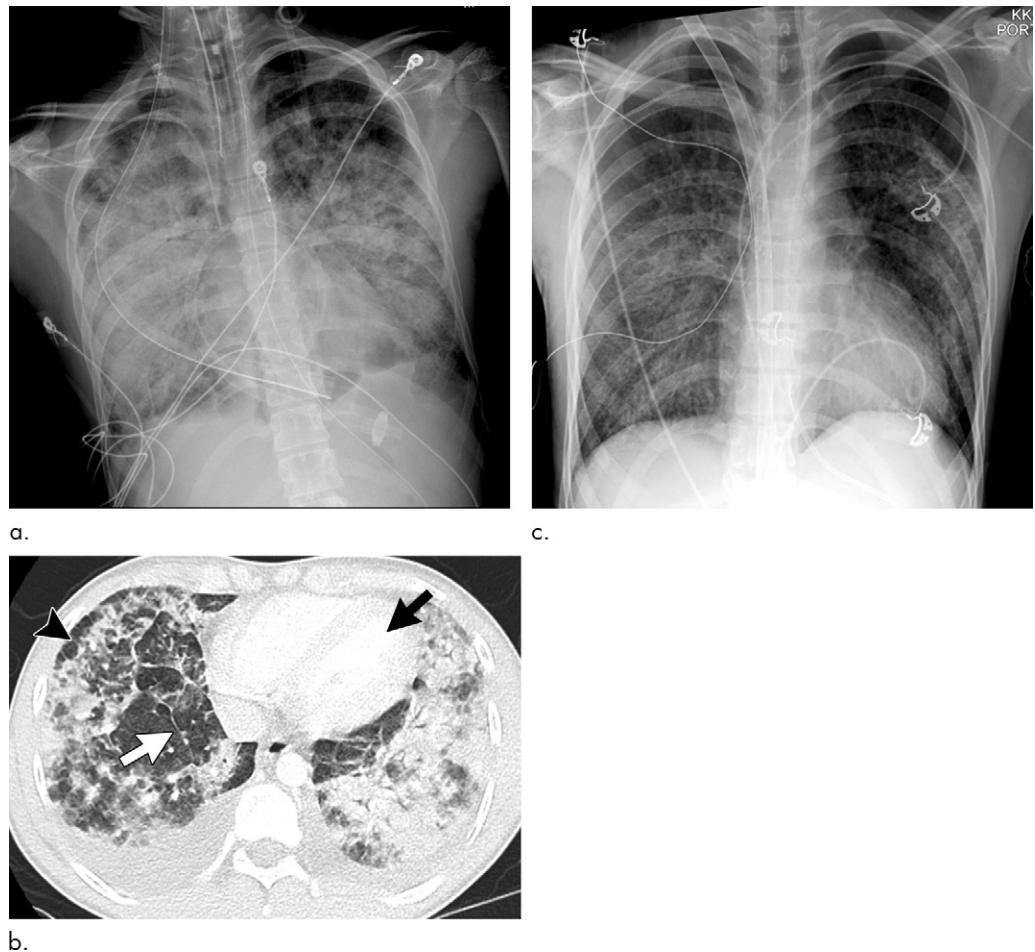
Images show electronic cigarette or vaping product use–associated lung injury secondary to acute eosinophilic pneumonia in a 21-year-old man who had been vaping nicotine and tetrahydrocannabinol products daily. (a) Posteroanterior radiograph 2 days after admission shows extensive consolidation. (b) Although imaging findings are often nonspecific, presence of extensive consolidation with areas of lobular and subpleural sparing (black arrowhead), such as that seen with diffuse alveolar damage, with associated prominent septal thickening (white arrow), moderate to large bilateral pleural effusions, and normal appearing left ventricle (black arrow), should raise possibility of acute eosinophilic pneumonia. Clinical diagnosis is also difficult because peripheral eosinophils are often not elevated until many days after start of symptoms. Patient's clinical condition and radiographic imaging continued to worsen and he was subsequently started on extracorporeal membrane oxygenation. Patient subsequently underwent bronchoscopy, which showed large percentage of eosinophils. (c) Three days after initiation of steroids, chest radiograph has significantly improved. (Images courtesy of Howard Mann, MBCh, Professor of Radiology, University of Utah.)
